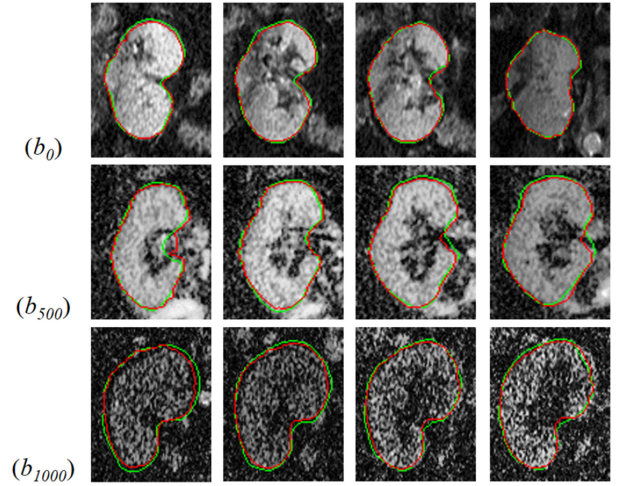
Additional four coronal cross-sections (columns) for our segmentation of the DW-MRI acquired at different b -values s/mm^2 .
